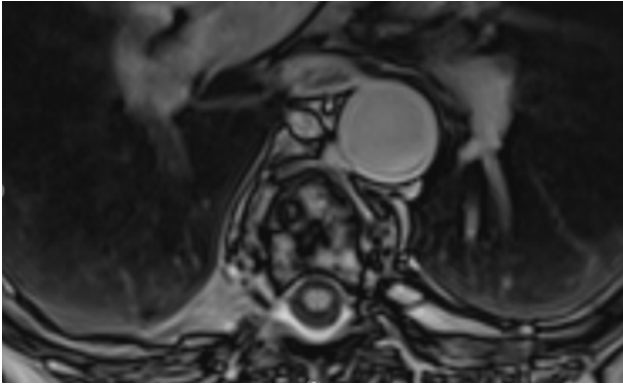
MRI of head and spinal cord four months after chemotherapy.
